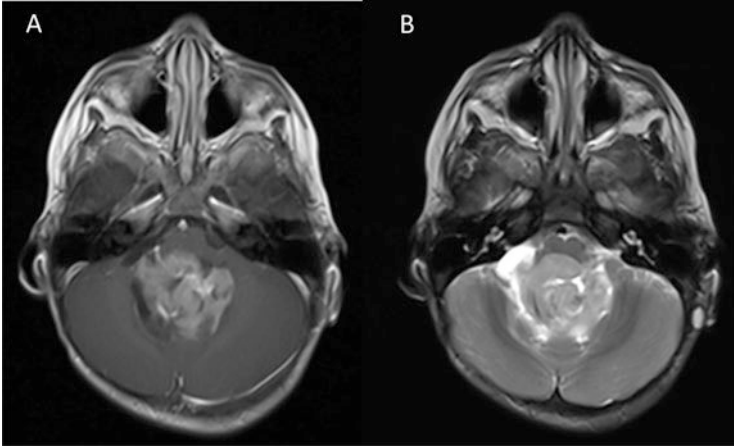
15-month male with ependymoma with cystic and solid components localized to the fourth ventricle measuring 3.9 × 3.4 cm. (a) T1 post-gadolinium image. (b) T2-weighted image
